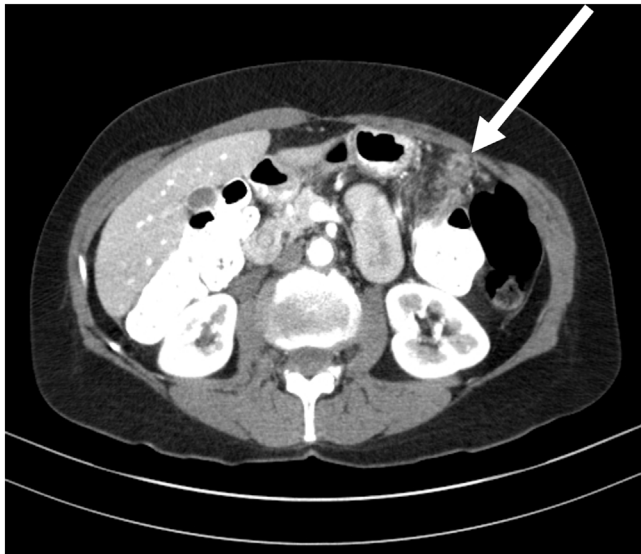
CT scan through the upper abdomen shows cancer infiltration of the greater omentum.
